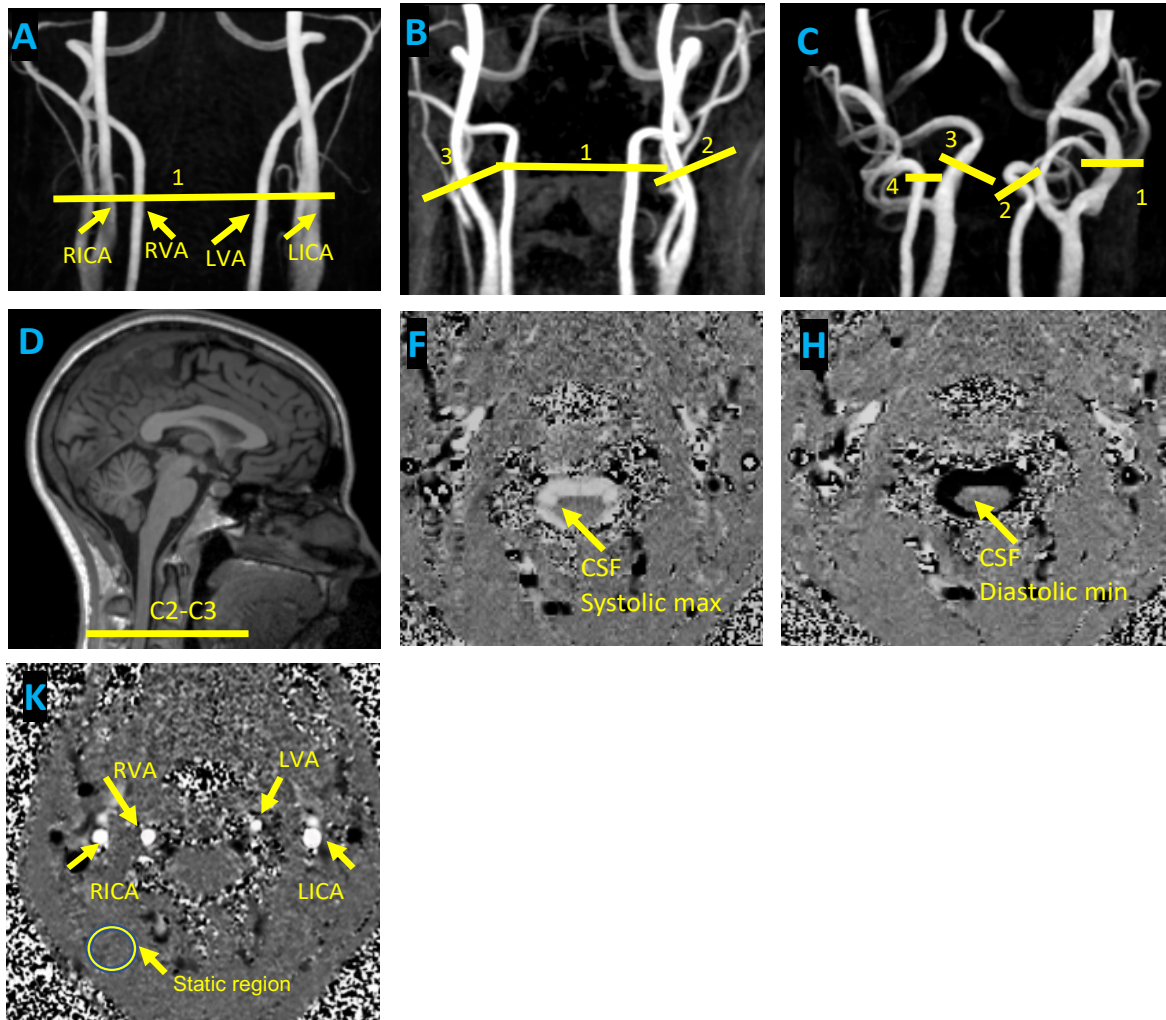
Examples of acquired MRI images; (A) Coronal view of 3D-TOF-MRA for a healthy young (26 years old) participant reconstructed with MIP algorithm. A transverse plane marked with yellow color was chosen to acquire arterial flow pulsatility from cervical arteries (B) healthy older adult 65 years old and, (C) healthy older adults 75 years. Both participants did not have known classical risk factors, no previous trauma or surgery in the neck. The tortuously shaped arteries in some of the older participants required an independent scan with a perpendicular plane for each artery (D) MPRAGE image showing the chosen transverse slice between C2 and C3 vertebrae. CSF measurement plane was selected from axial reconstruction of MPRAGE where the spinal canal is between C2 and C3 vertebrae (F) CSF spinal canal at systolic peak (H) CSF spinal canal in diastolic peak (K) Transverse slice showing Left ICA (LICA), right ICA (RICA), left VA (LVA), right VA (RVA). Transverse plane for measuring arterial pulsatility was selected using 3D-TOF-MRA at cervical subarachnoid space between C2 and C3 vertebrae above bifurcation.
